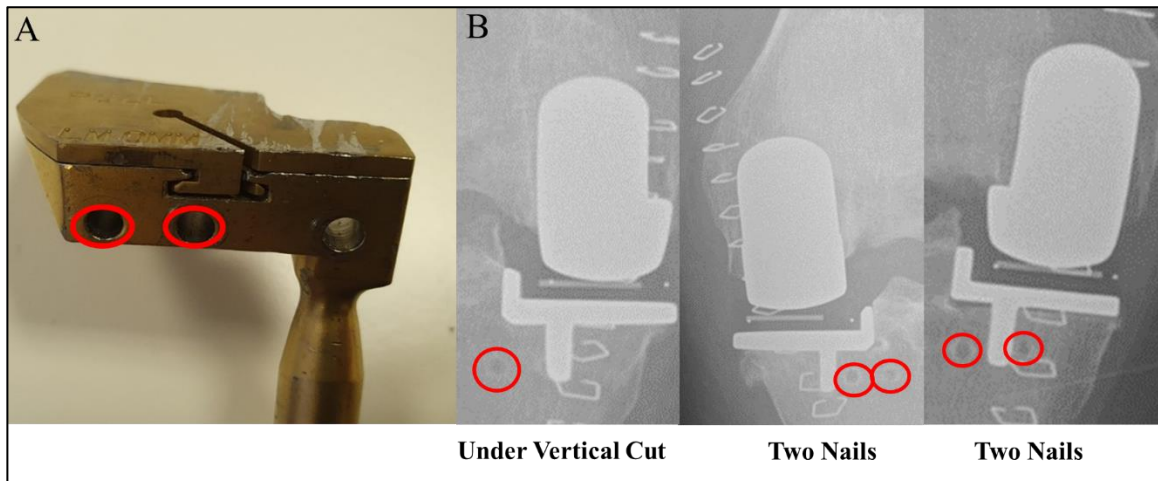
A The tibial resection guide with the two medial nail holes that are most used by surgeons (circled in red). B Examples of nail holes (circled in red) in the proximal tibia on post-operative radiographs of patients who received an Oxford Unicompartmental Knee Replacement.
